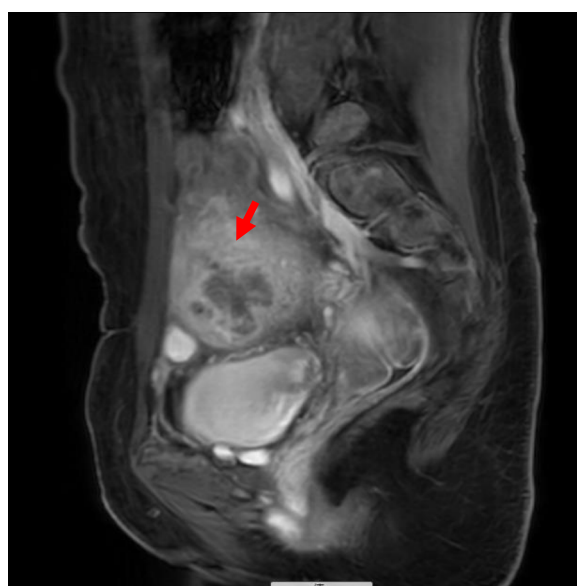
Mass in pelvic MRI (red arrow)
